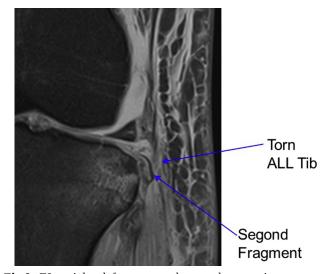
T2-weighted, fat-saturated coronal magnetic resonance image of a left knee revealing a Segond fracture with attachment of the tibial portion of the anterolateral ligament (ALL Tib) to the fragment.
